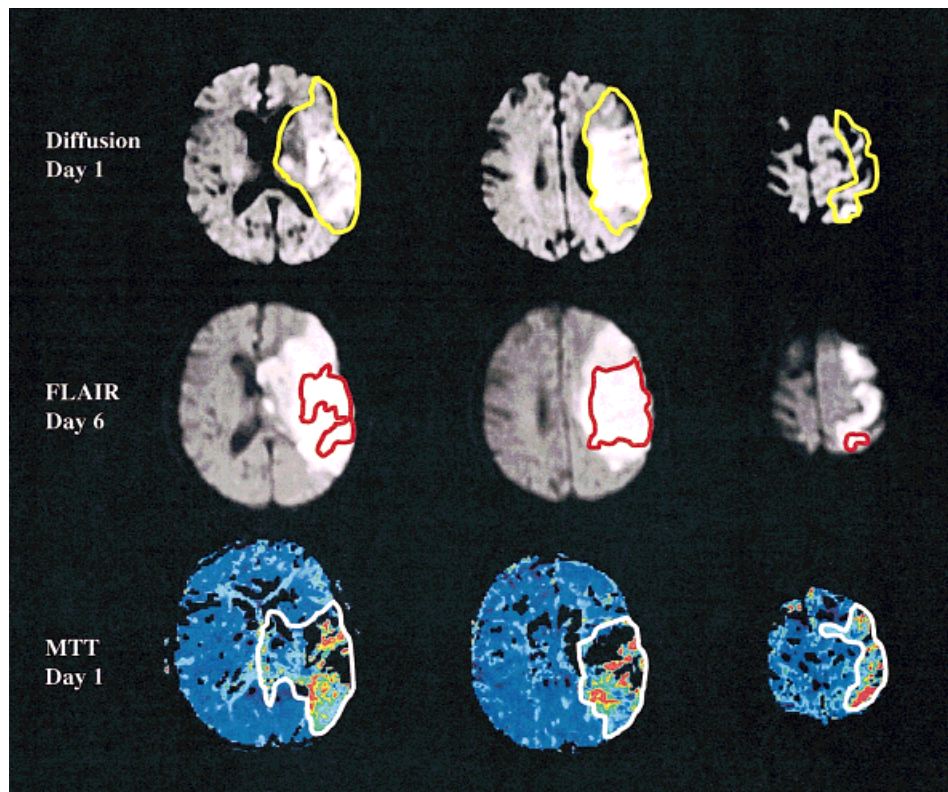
Top row: Diffusion images acquired within 6 hours of stroke symptom onset. The yellow ROI (corrected for ventricular edema) depicts infarct size 5 days later (266 cm^3) as drawn on the FLAIR images from middle row. Middle row: FLAIR images acquired 5 days later. Red ROI depicts infarct size (78 cm^3) as drawn on initial diffusion images (top row). Bottom row: MTT images calculated from data collected within 6 hours of stroke onset. White ROI (180 cm^3) depicts the regions with abnormal MTT values compared to the contralateral mirror region. The size of the penumbra region (white ROI - red ROI) was 102 cm^3 . Note that the final infarct size was even larger than the penumbra as defined by the MTT images and that in order to study the full extent of the penumbra and infarct regions, a multislice or whole brain acquisition was needed when acquiring the bolus tracking images. Not all slices containing the infarct and penumbra are shown.
